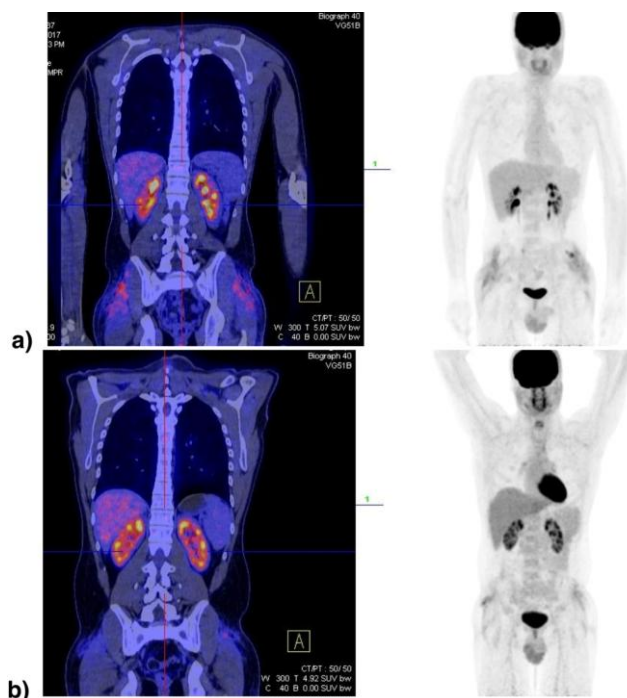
PET CT in a patient with ECD initially revealed high metabolic activity in the gluteal region with deep subcutaneous infiltration and muscle affection (SUV max 6.0) (a) and 4 months after treatment initiation with a significant reduction of the tumour mass and infiltration (SUV max 2.3) (b)
